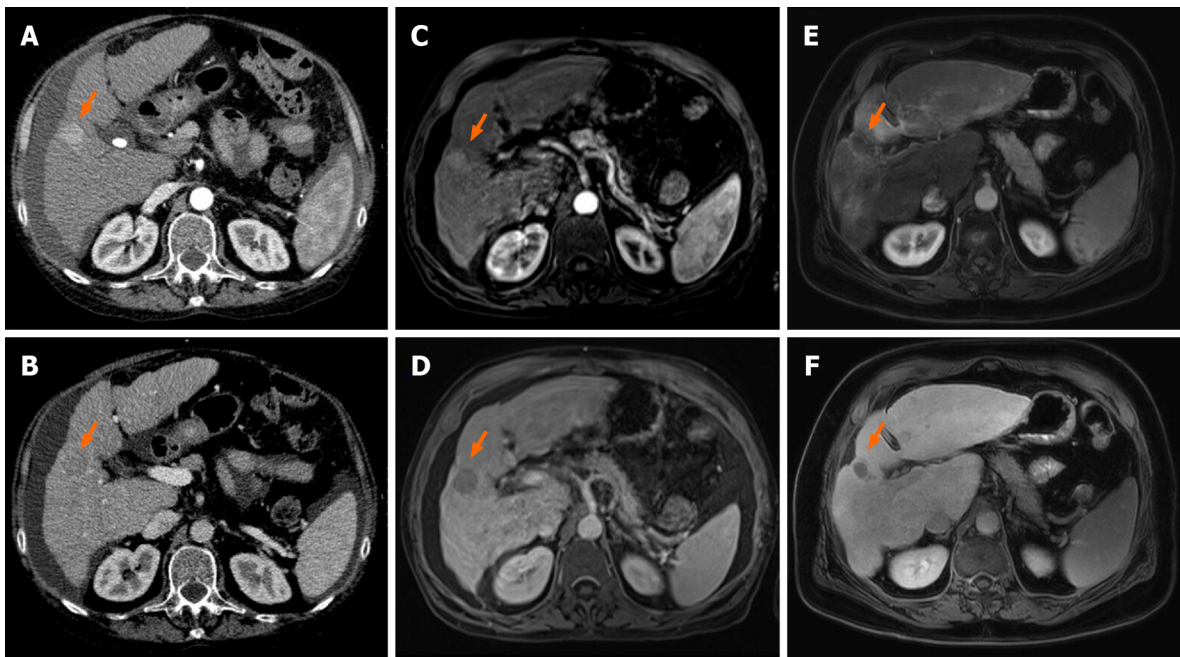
Imaging from before and after combination therapy in one patient in the transarterial chemoembolization + stereotactic body radiation therapy cohort. A, B: Contrast enhanced computed tomography (CT); C-F: Magnetic resonance imaging (MRI). Contrast enhanced CT and MRI, arterial phase (top row) and portal venous phase (bottom row) cross sectional imaging from before (A–D) and after (E, F) treatment. At baseline CT and MRI, a well-defined nodular lesion with typical contrast agent dynamics is noted in the right liver lobe (Arrows). After treatment, typical radiation induced peri-lesional hyperenhancement and no hepatocellular carcinoma-specific contrast agent uptake is noted.
